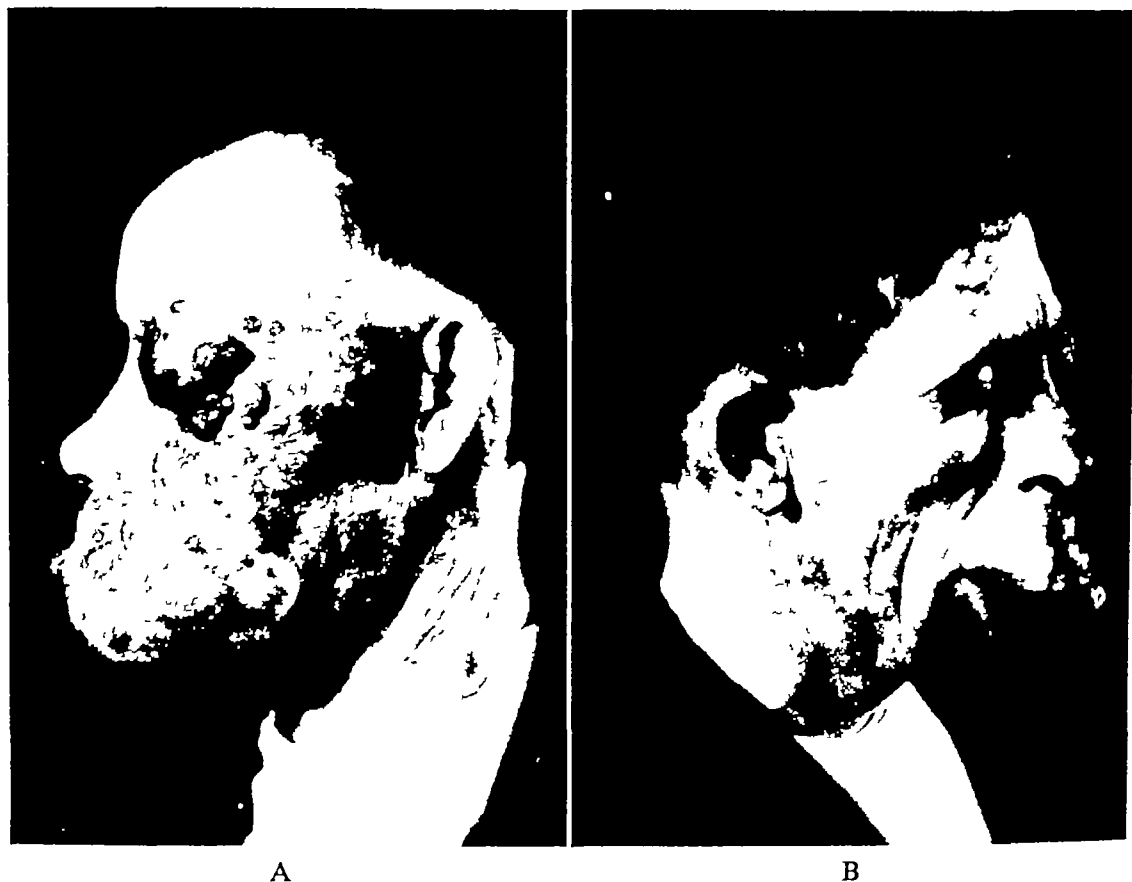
A and B Huge cavernous hemangioma seen at the age of 36 in S B The external carotid artery was divided distal to the superior thyroid artery Multiple injections of sclerosing solution were given into vascular dilatations in the lids, cheek and upper lip Deep x-ray therapy was administered externally and intraorally A wedge-shaped resection of the upper lip and cheek were done The eyelid was later under plastic surgical care (Dr P W Greeley) Patient was re-examined 20 years after surgery His condition was originally described by the county supervisor as horrible, revolting and repulsive "It is hard to understand how Divine Providence could allow such an affliction to befall a human being" Following the operation he married, and now has children and a good job in a Michigan community.
